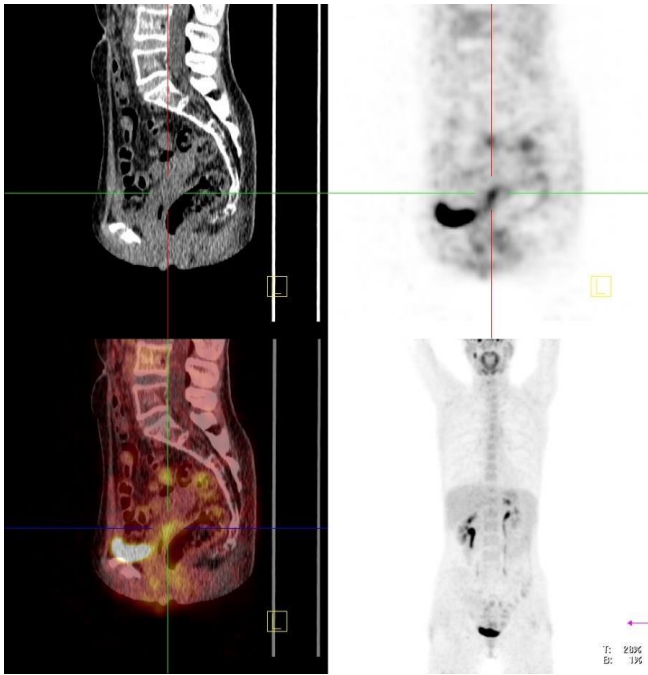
FDG PET/CT images (sagittal CT, PET and fusion, as well as MIP) of a patient (43 years). There is a focal enhancement of radiopharmaceuticals in the uterus, indicating a local recurrence of the cancer.
